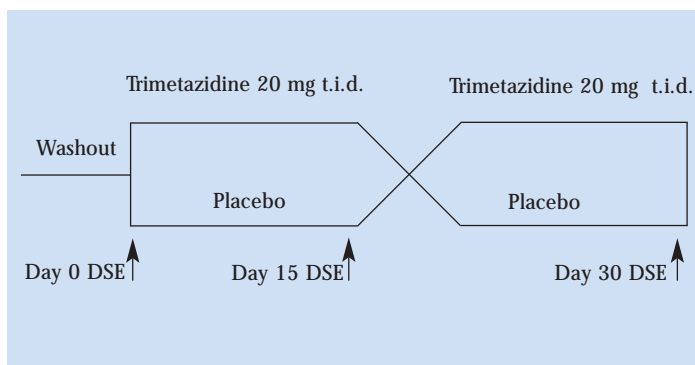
Study design for trimetazidine in coronary artery disease patients with ventricular dysfunction. DSE, dobutamine stress echocardiography.
